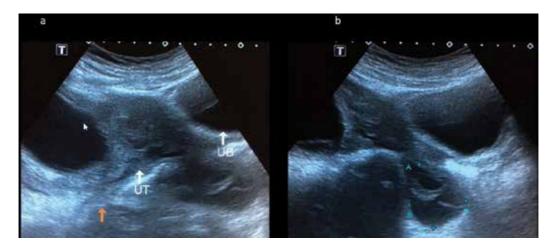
Grey scale ultrasound scans demonstrating suspicious bilateral large adnexal masses in a postmenopausal woman. The white arrow on the left indicates the uterus, the white arrow on the right indicates the urinary bladder and the orange arrow indicates the thick-walled right adnexal mass. Image (b) shows the dimensions of the left adnexal mass.
